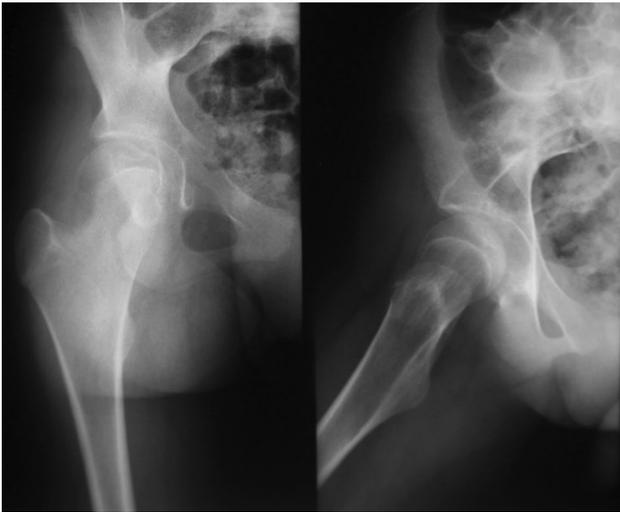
Preoperative X-rays of the girl
